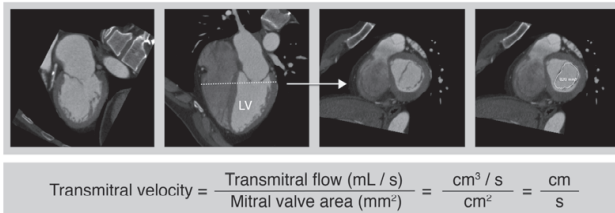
Diastolic left ventricular (LV) function assessed with multidetector row computed tomography (MDCT).
